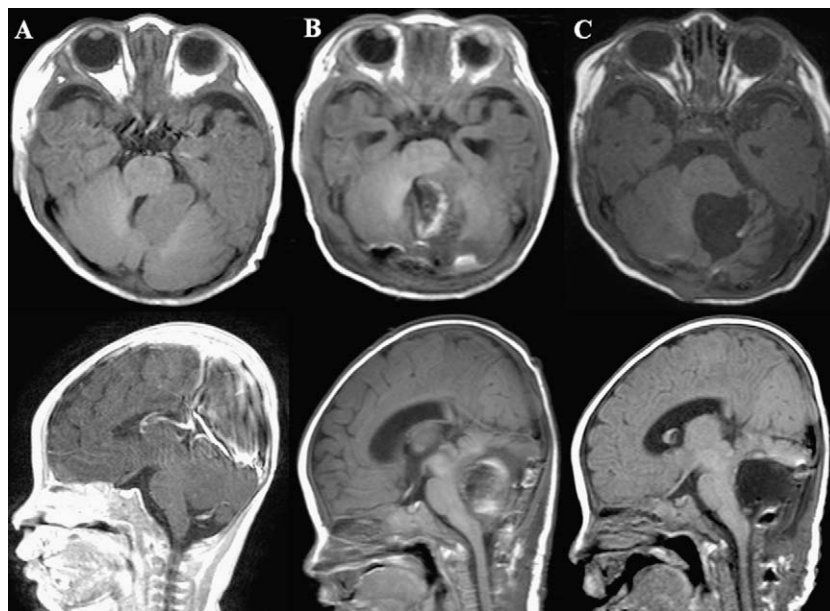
Brain MRI. (A) Preoperative T1-weighted image was taken in axial and sagittal plan, (B) after the first operation, a heterotopic gray matter mass remained in left cerebellar hemisphere and middle cerebellar peduncle and (C) complete resection achieved after second operation.
